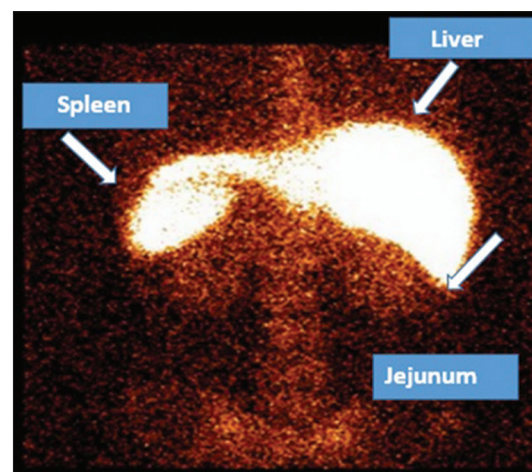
Human serum albumin scintigraphy demonstrating the exudation of proteins from the distal jejunum and ileum – suggestive of protein-losing enteropathy
